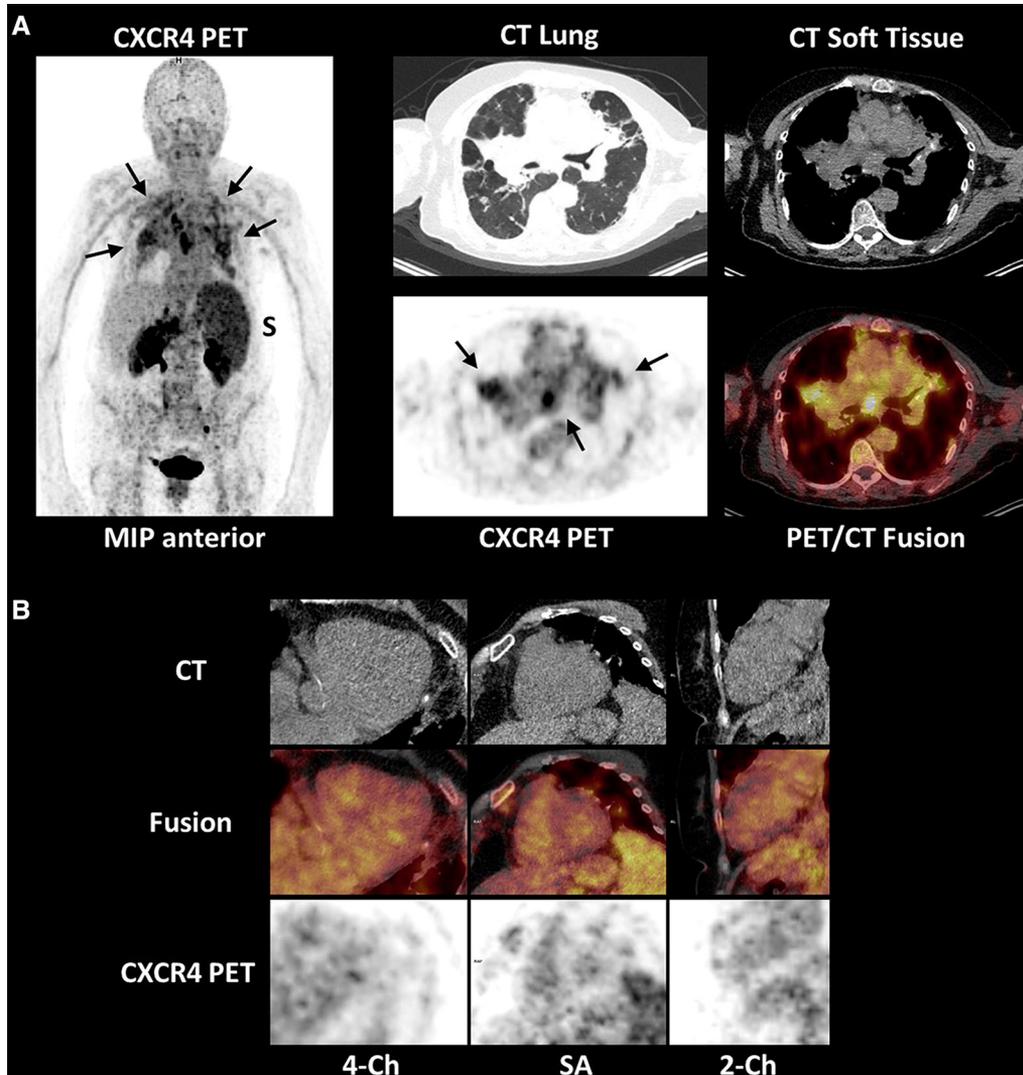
Clinical case study imaged with a new inflammation-specific tracer. Shown are whole-body and cardiac PET/CT images using the chemokine receptor CXCR4-targeted tracer, ^{68}Ga -pentixafor, in a patient with newly diagnosed sarcoidosis, confirmed by hilar lymph node biopsy. A Whole-body images show clear uptake in multiple lung lesions and mediastinal lymph nodes (arrows), along with enlarged and active spleen (S), consistent with the presence of CXCR4-positive leukocytes and thus with active systemic inflammation. B Cardiac images show lack of background activity and definite absence of focal lesions, ruling out the presence of cardiac involvement. *CT*, computed tomography; *PET*, positron emission tomography; *CXCR4*, CX-motive chemokine receptor type 4; *MIP*, maximum intensity projection; *4-Ch*, four-chamber view; *SA*, short axis view; *2-Ch*, dual-chamber view.
